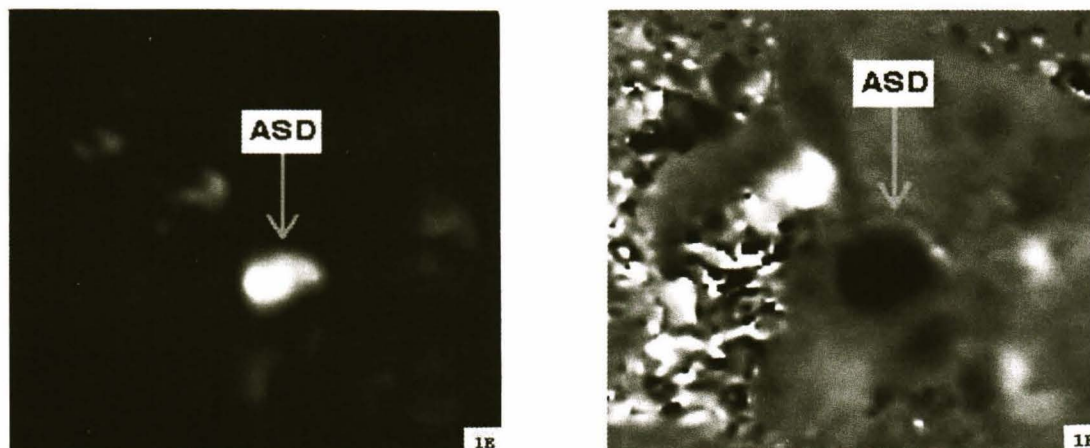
1F. Cardiac MRI of ASD flow sensitive gradient-echo pulse sequence showing companion view of the en-face view
